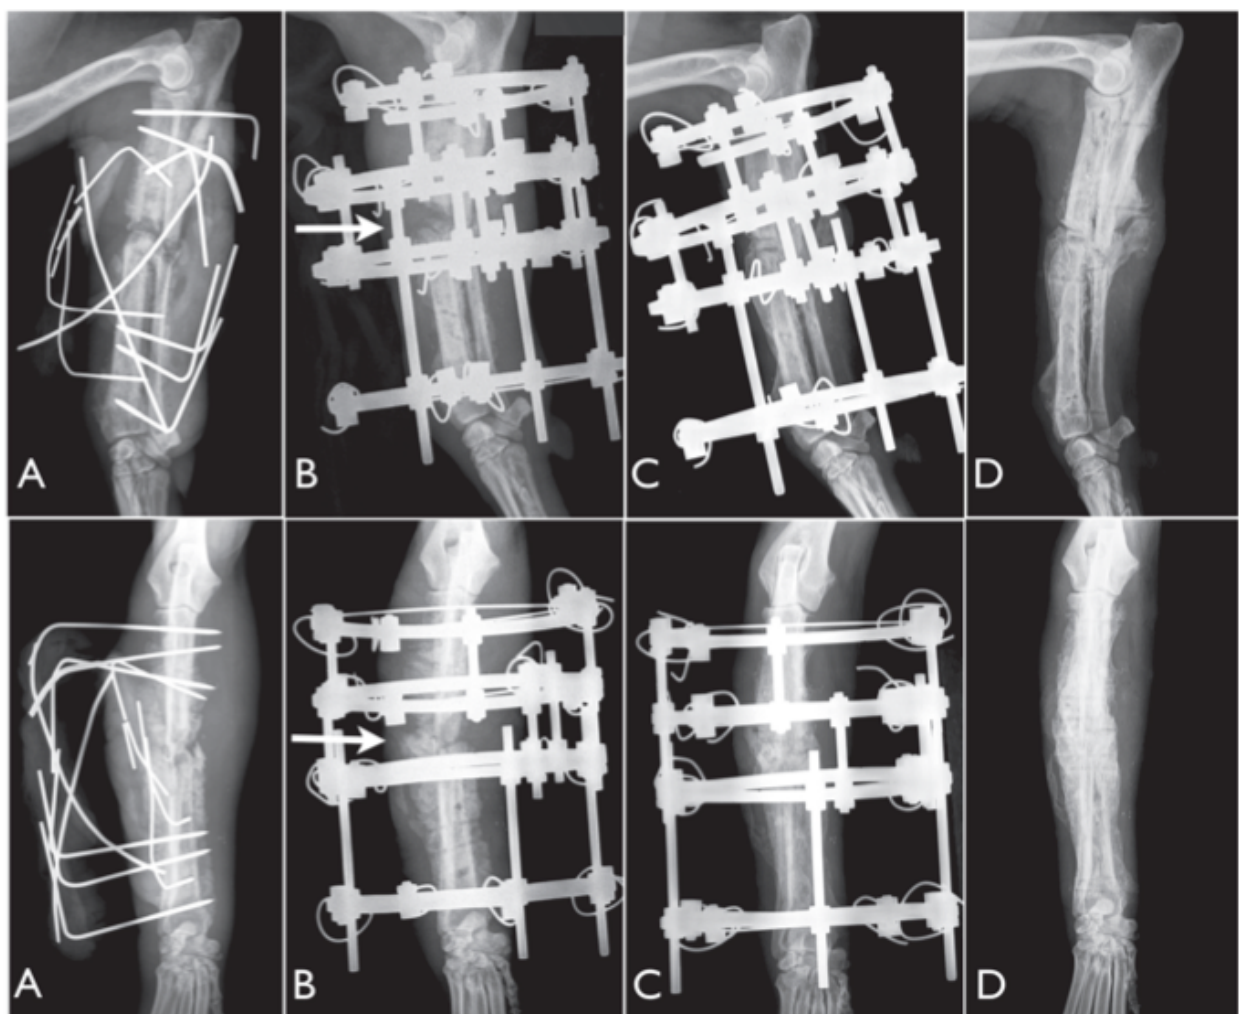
Radiographic images from case 7. A) Preoperative medio-lateral (upper panel) and cranio-caudal (lower panel) views: mid-diaphyseal radius-ulna oligotrophic septic nonunion in a eight-year-old 18 kg mongrel. An acrylic type Ia linear external skeletal fixator was applied 30 days prior to stabilize the fracture. Note the small diameter of the pins used. B) Immediate postoperative medio-lateral and cranio-caudal views. A traditional Ilizarov
